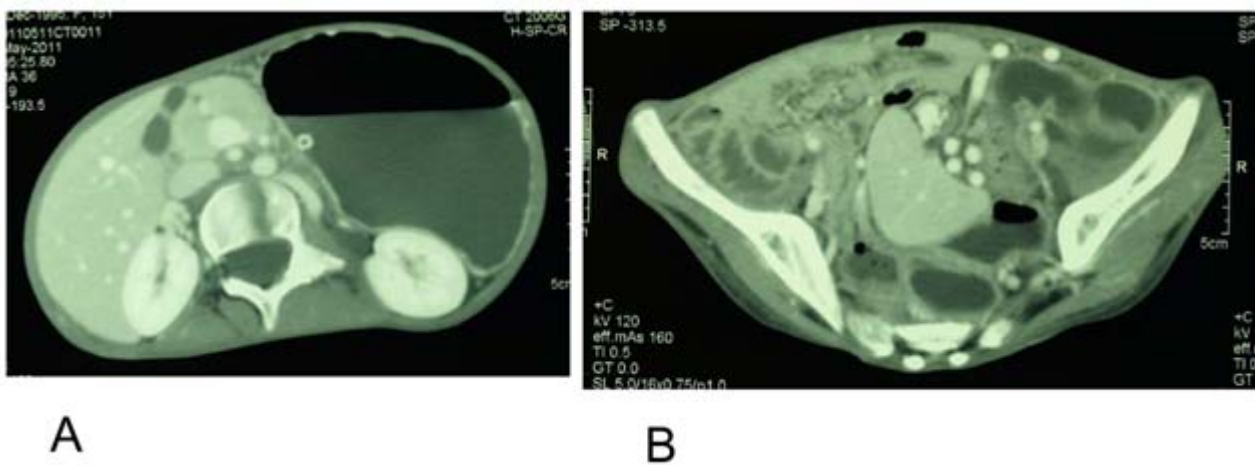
Computed tomography of the abdomen shows gastric dilatation (A) and malposition of the spleen (B) in the pelvis.
